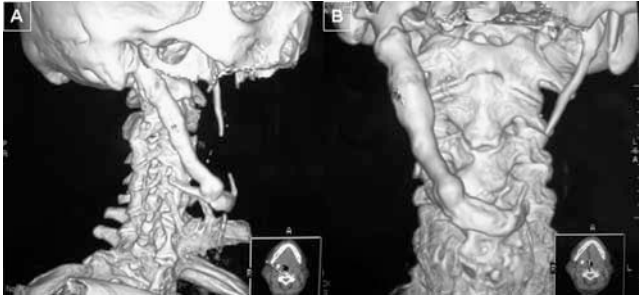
A and B. 3D reconstruction of computed tomography scan images.
